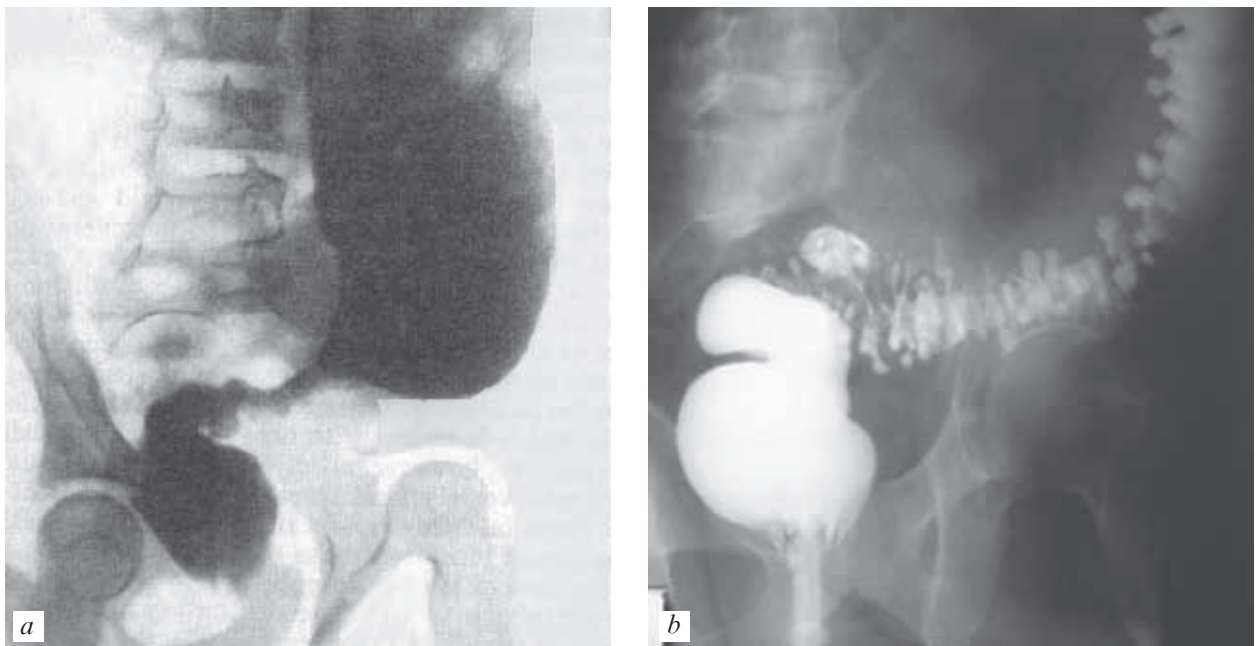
Hirschsprung's disease. X-ray of the large intestine (barium in suspension enema). A constriction continuous with a dilated part of the large intestine is seen in the rectosigmoid zone (a, b)
